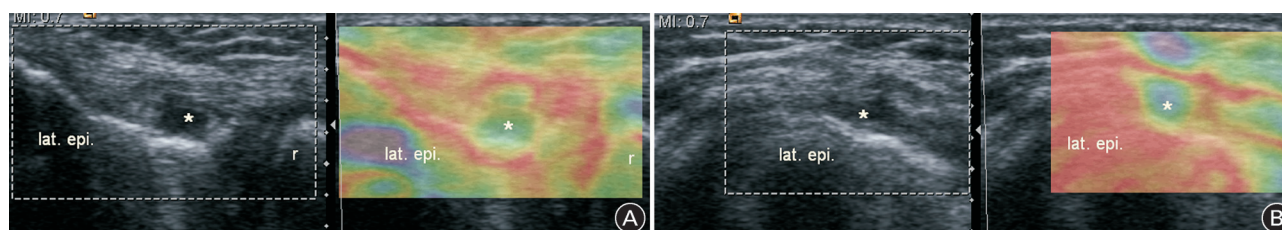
Greyscale ultrasonographic and sonoelastographic images of a partial-thickness tear of the common extensor tendon in a 38-year-old female violinist (A: longitudinal view; B: transverse view). The ultrasonographic images (left) depict areas of softening (asterisks; sonoelastographic score 1 (soft)); note the purple-to-green contrast to the surrounding red area in the sonoelastographic images (right). lat. epi.=lateral epicondyle; r=radial head.
